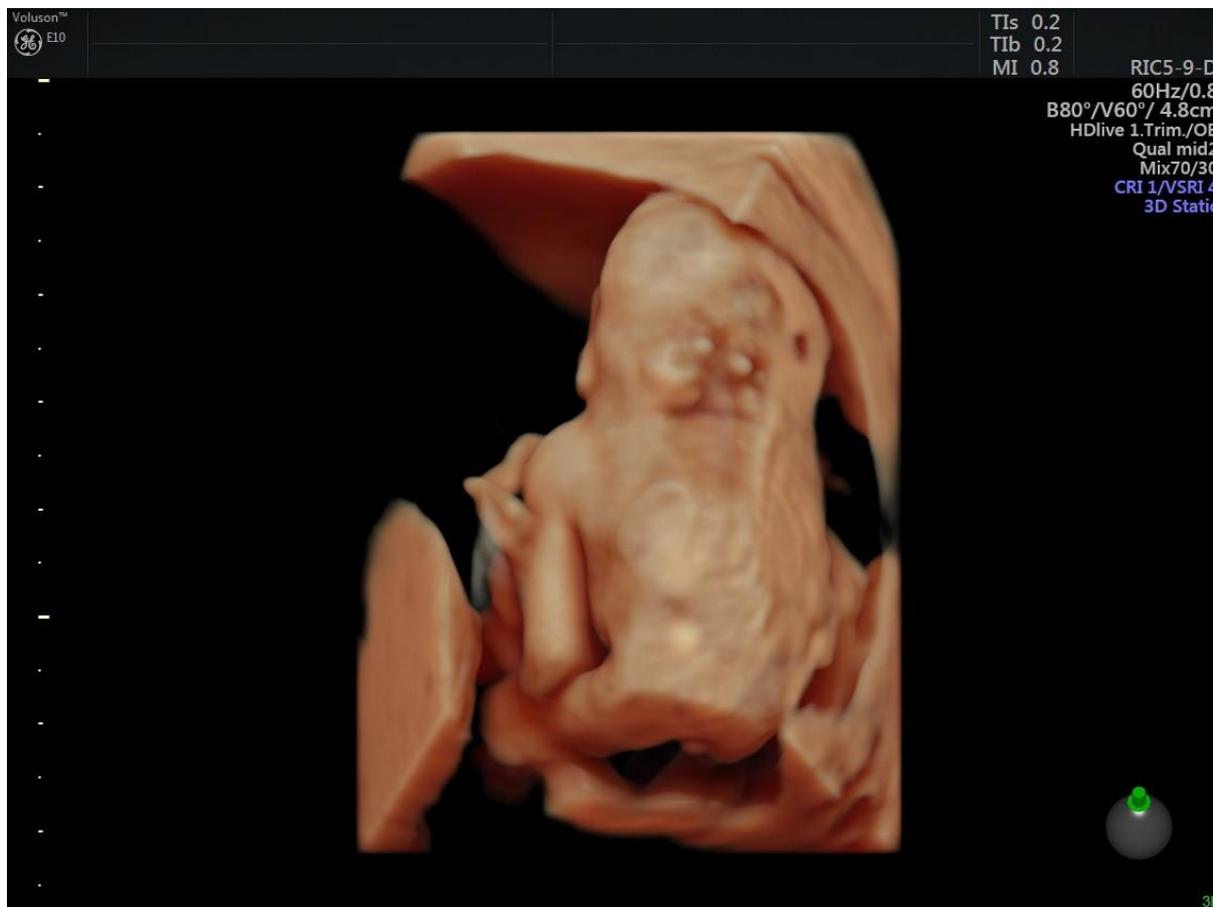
Fetal anencephaly. First trimester ultrasonography, 3D Static examination.
